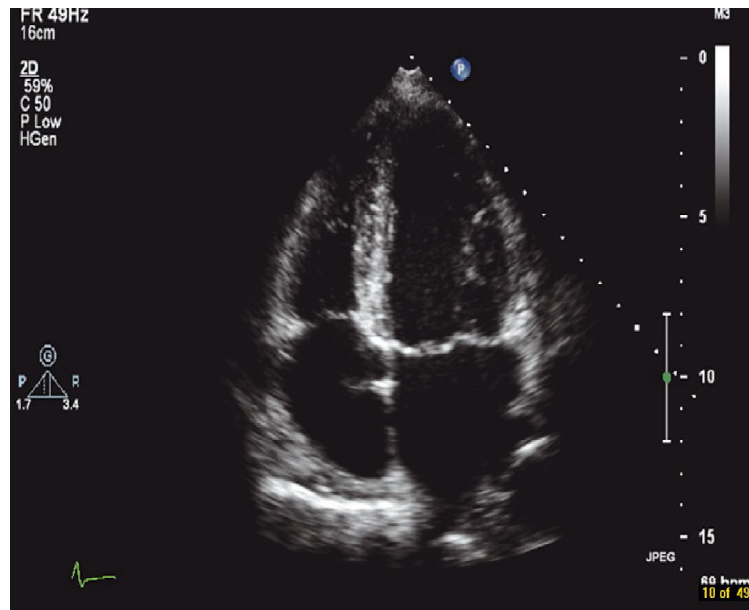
shows normal apical 4-chamber view(Houghton, 2013).
